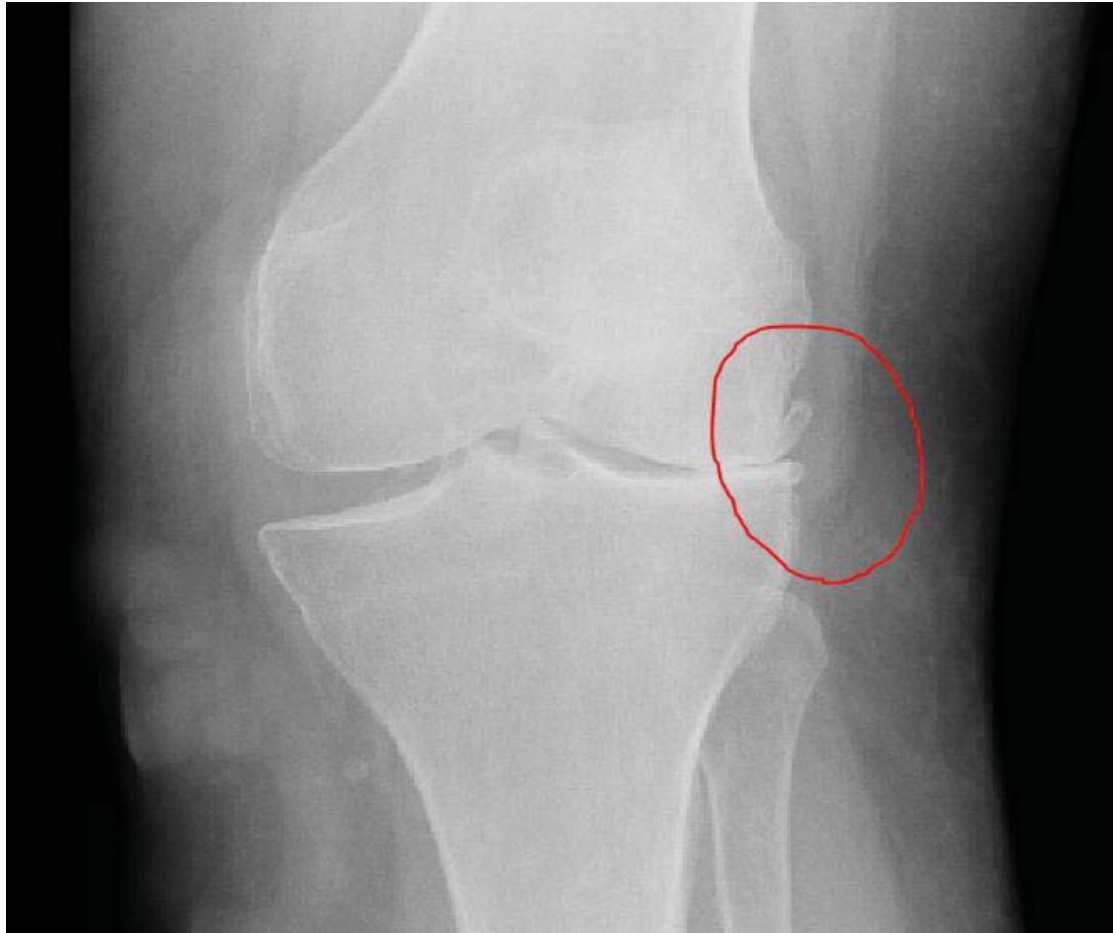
Sample of X-ray OPs
